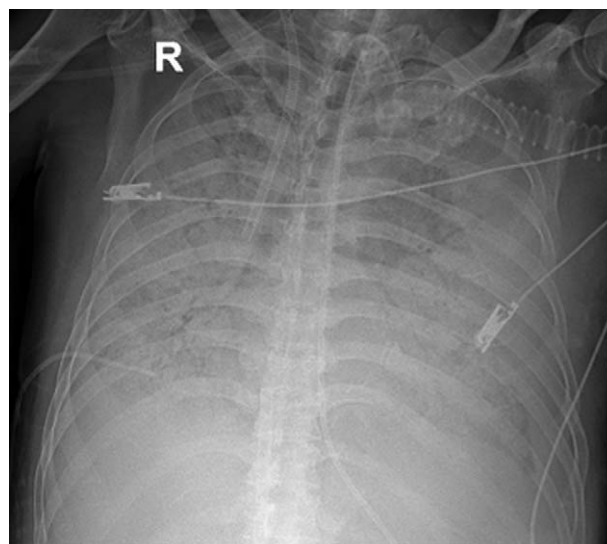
Chest X-ray revealing a rapid progression of infiltrative lesions in both lungs.
